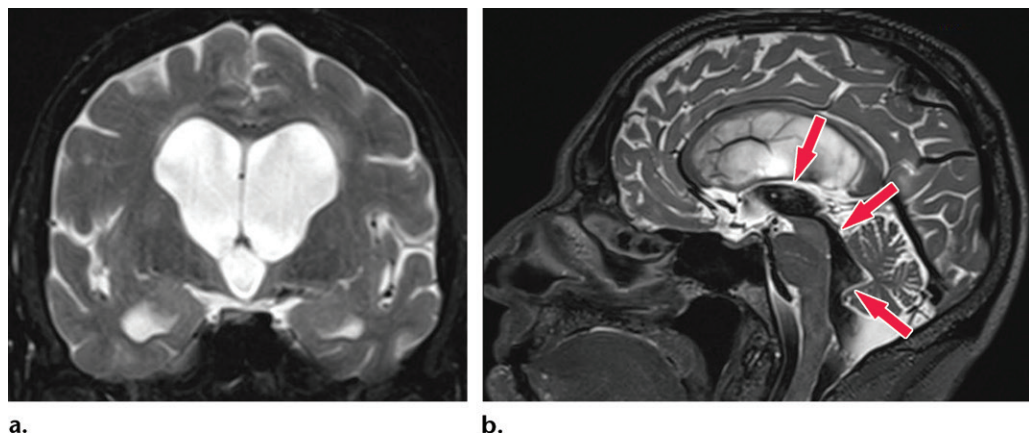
Patient with normal pressure hydrocephalus with insidious onset of dementia, gait disturbance, and urinary incontinence. Coronal T2-weighted (a) and sagittal T2-weighted three-dimensional–volumetric high-spatial-resolution (b) MR images show ventriculosulcal disproportion, which is suggestive of normal pressure hydrocephalus. Three-dimensional–volumetric high-spatial-resolution images also show a large cerebrospinal fluid flow void (arrows) at the level of the third ventricle, cerebral aqueduct, and fourth ventricle, suggesting increased velocities and excluding obstruction, which helps confirm normal pressure hydrocephalus.
